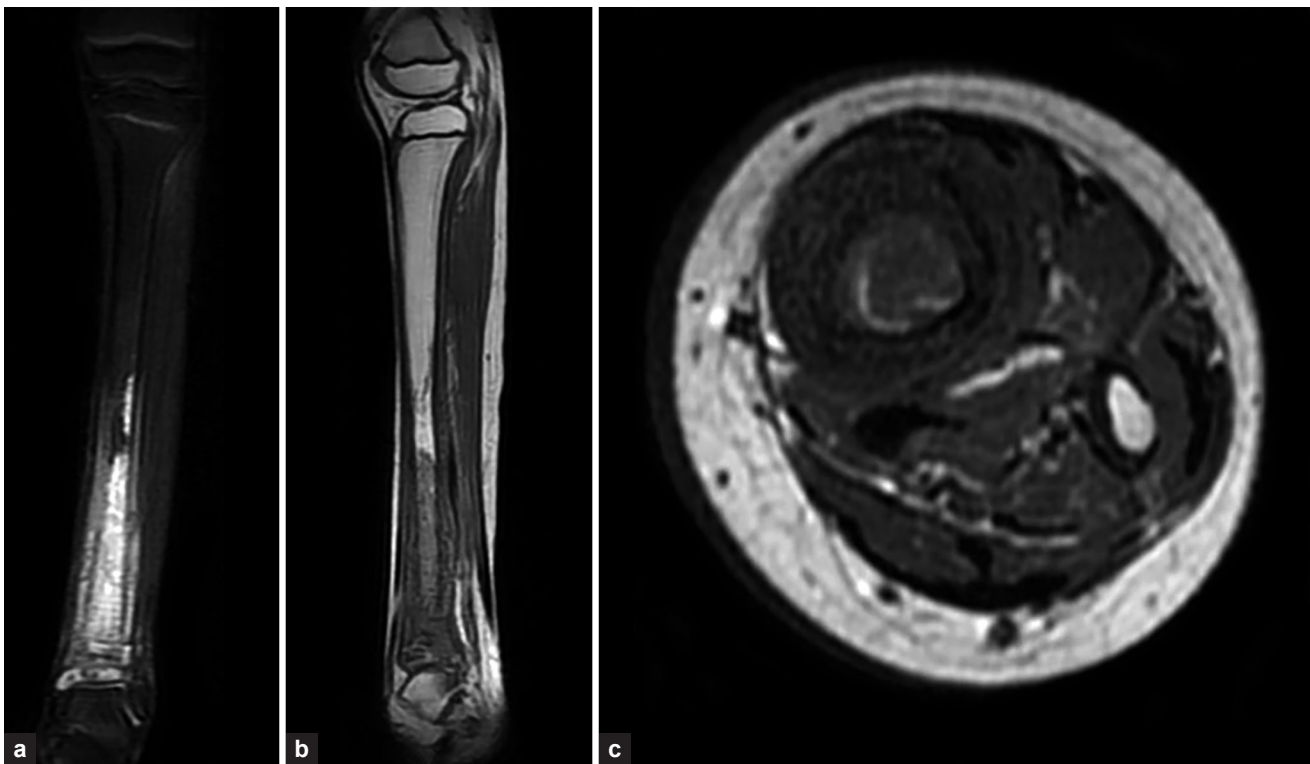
(a to c) Ewing's sarcoma distal end of tibia. Magnetic resonance imaging: (a) Coronal T2-weighted image; and (b) Sagittal T1-weighted image showing the intramedullary extent of disease; (c) T1-weighted axial image showing osseous involvement with minimal circumferential soft tissue component. Neurovascular bundle is free
